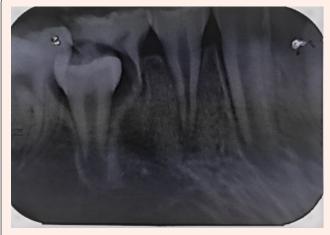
Periapical radiograph taken before treatment. Periapical lesion around immature apex of mandibular right first premolar due to fractured Dens evaginatus
